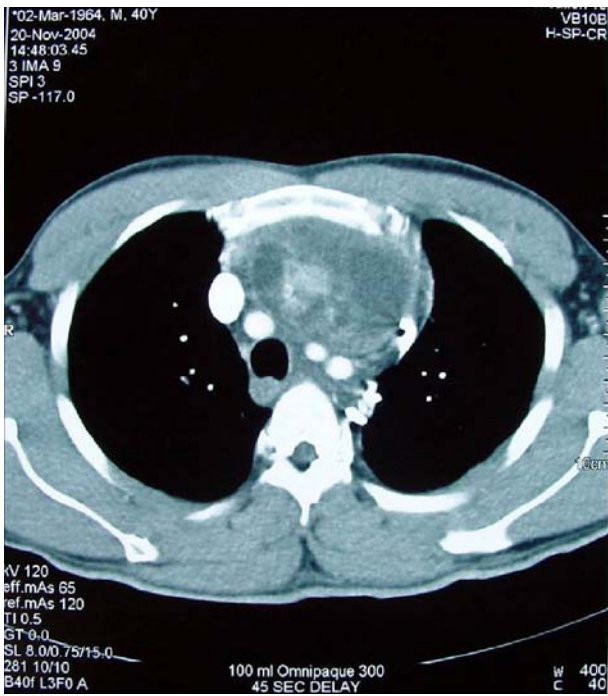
MRI showing anterior mediastinal cyst
